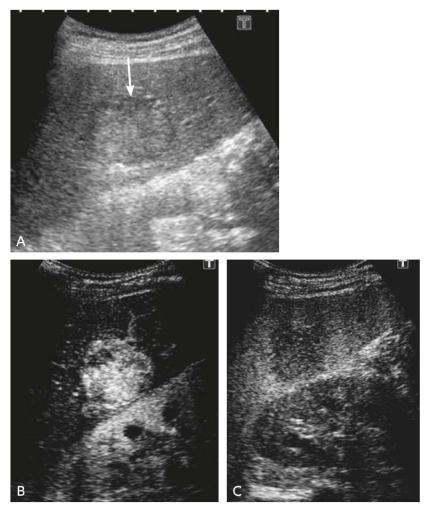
Ultrasound images (moderately differentiated hepatocellular carcinoma)
